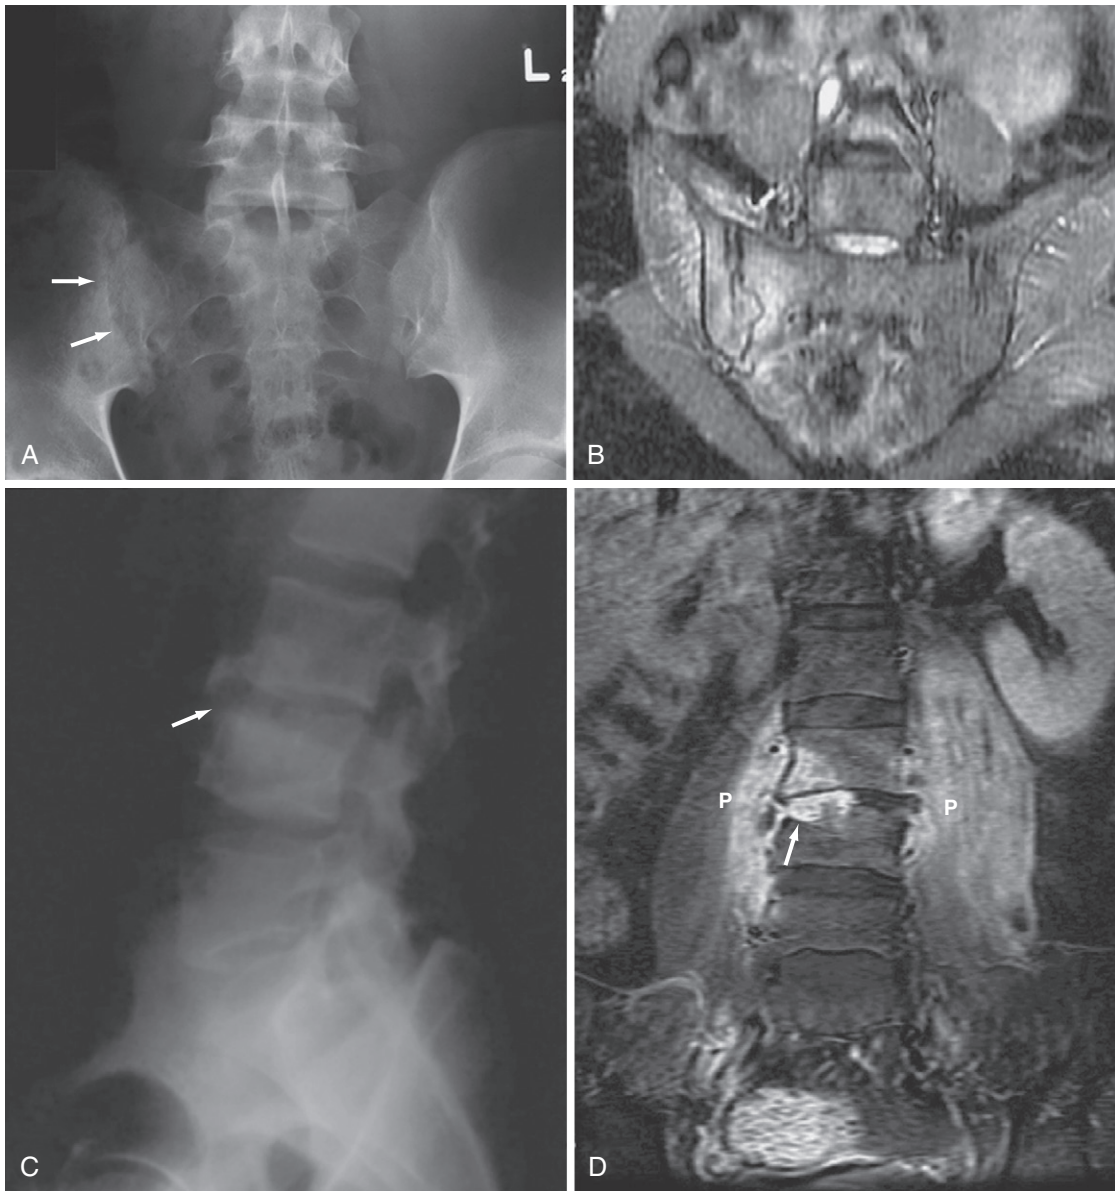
Septic arthritis (x-ray and magnetic resonance imaging [MRI]). A, X-ray in anteroposterior view of sacroiliac joints shows destruction of the right sacroiliac joint as part of septic arthritis (arrows). B, In another patient, short tau inversion recovery (STIR) coronal MRI through sacroiliac joints shows erosive changes in the right sacroiliac joint with extensive bone marrow edema. C and D, Tuberculous spondylitis. C, X-ray of the lumbar spine in lateral view shows disk space narrowing at the L3-L4 level with destructive changes involving the superior end plate of the L4 vertebral body (arrow). D, Coronal STIR MRI of the lumbar spine of the same patient confirms focal destruction of the L4 vertebral body (arrow). Enlargement of both psoas muscles (P) with increased signal is noted, owing to paraspinal extension of the infection.
